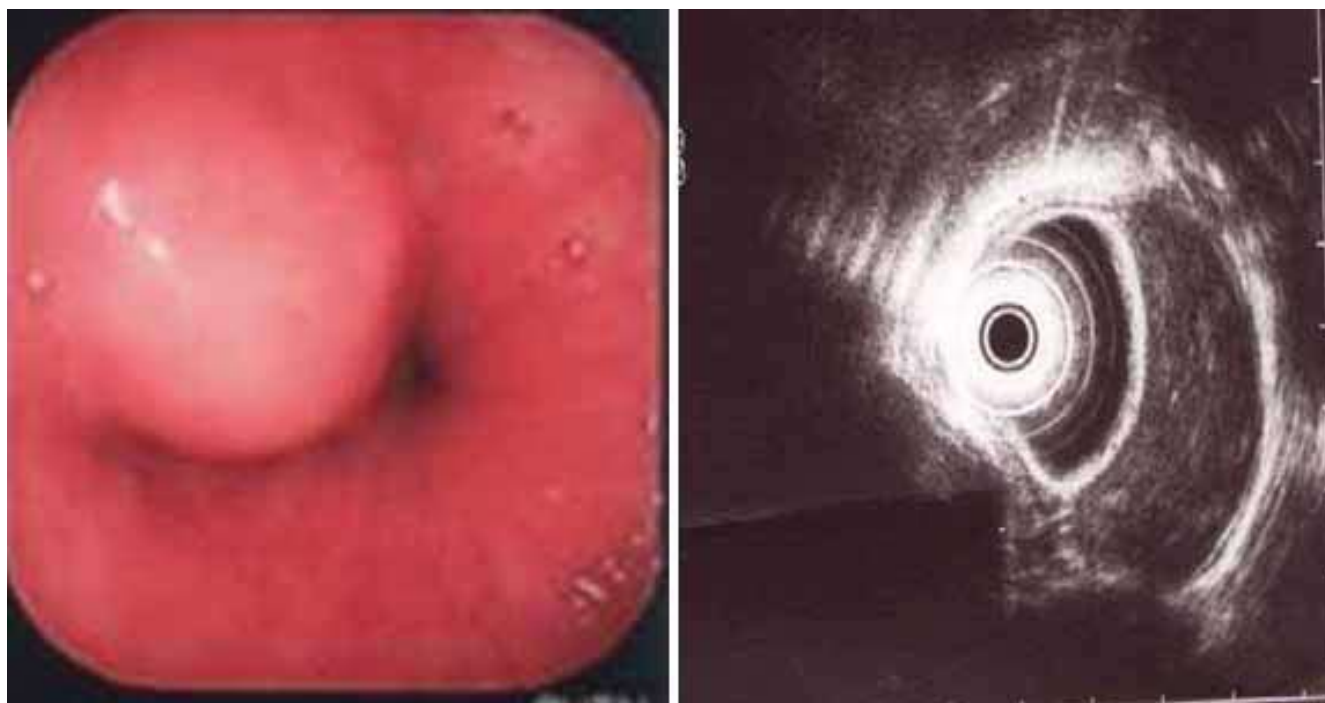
a. Endoscopic image of a submucosal leiomyoma and b. endoscopic ultrasound of an esophageal leiomyoma.
